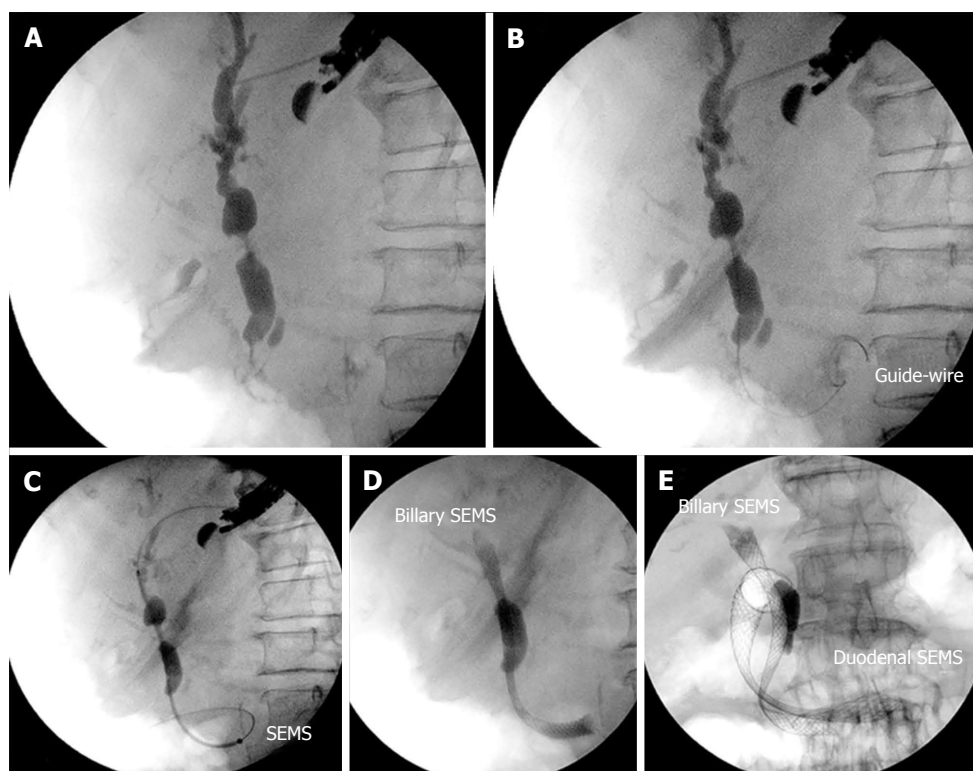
Patient with duodenal stenosis due to a pancreatic carcinoma. A: Endosonography (EUS)-guided cholangiography; B: Insertion of the guidewire through the duodenal major papilla and positioning in the duodenum; C: Anterograde insertion of the self-expandable metallic stents (SEMS) through the gastric wall across the duodenal major papilla and its positioning in the duodenum; D: Deployment of the SEMS; E: Insertion of the duodenal SEMS. SEMS: Self-expandable metallic stents.
